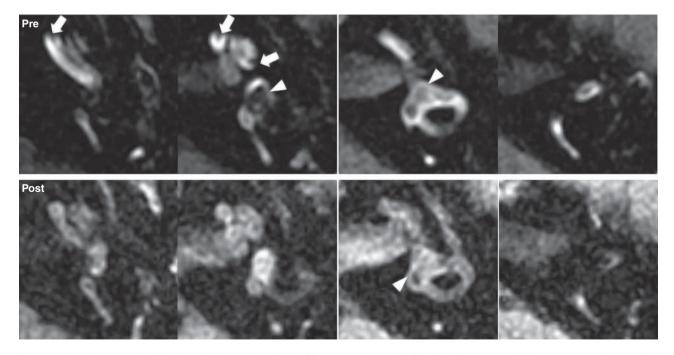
Another example of reduced hydrops (case P34). Upper panels are 2D-FLAIR MR images of Gd contrast medium applied intratympanically before sac surgery. Lower panels are images of Gd contrast medium applied intravenously in the same patient 6 months after surgery. The intratympanic application gave clearer contrast images, but the intravenous application was comparable. Cochlear and vestibular hydrops were clearly seen before surgery, but both disappeared after the surgery. Arrows and arrowheads indicate the endolymphatic space in the cochlea and the vestibule, respectively.
